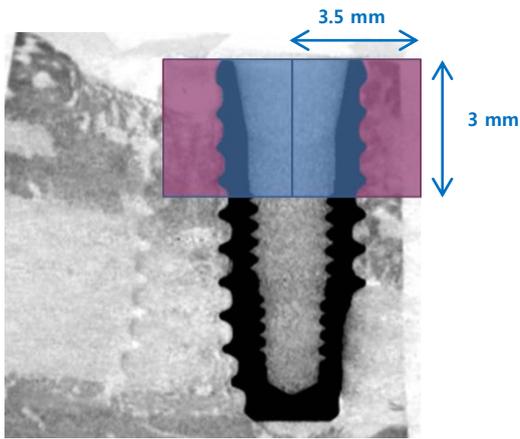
Bone volume measuring range in micro CT image
